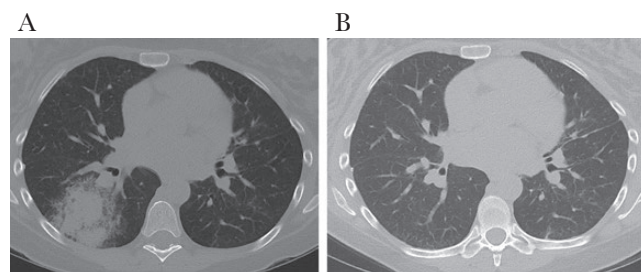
A, Chest computed tomography (CT) at the time of presentation with infection at 21 weeks gestational age. B, Chest CT at 1 day postpartum.
